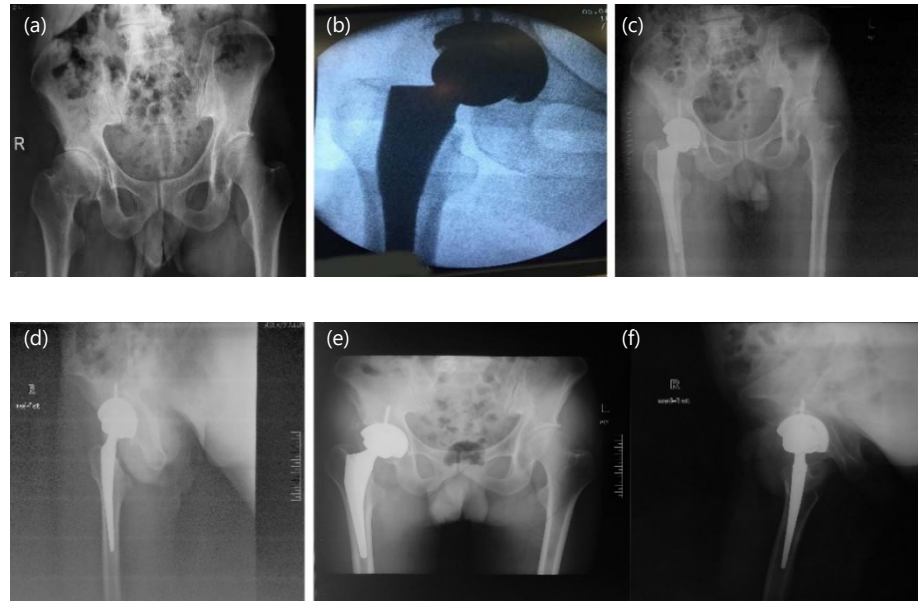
(a-f): Radiographs of a 53 years-old male patient with femoral head primary osteoarthritis of the right hip. (A) Preoperative plain radiograph of the pelvis, (b) Acetabular cup as viewed by c-arm, (c) Postoperative AP and (d) Med-lateral plain radiographs of the pelvis showing Total hip arthroplasty performed via direct anterior approach. Postoperative, (e) AP and (f) Med-lateral plain radiographs 3-months after the surgical procedure
